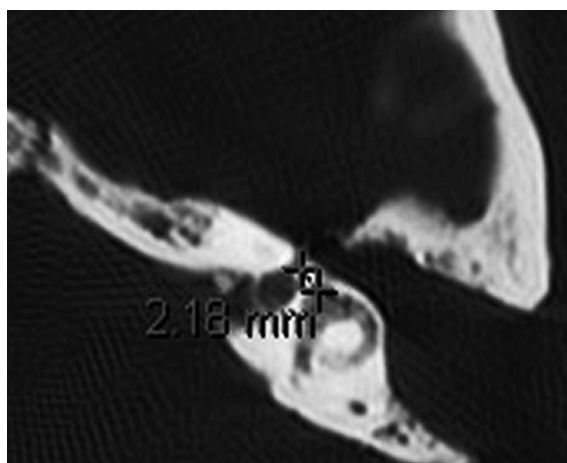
The distance of between the LS and the vestibule (a) and the LSC (b) on the axial temporal bone HRCT scan.
